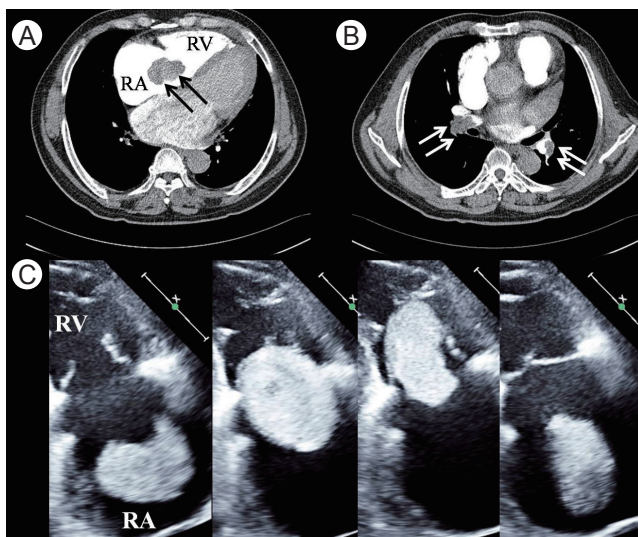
(A, B) Computerized tomographic images showing a mass floating in the right heart (A, black arrows) and embolism in both pulmonary arteries (B, white arrows). (C) A series of echocardiographic images of the right heart. A huge deformable echogenic mass in the enlarged right atrium (RA) is floating and plugging the right ventricle (RV) during diastole (the first three images) and ejected out during systole (the last).
